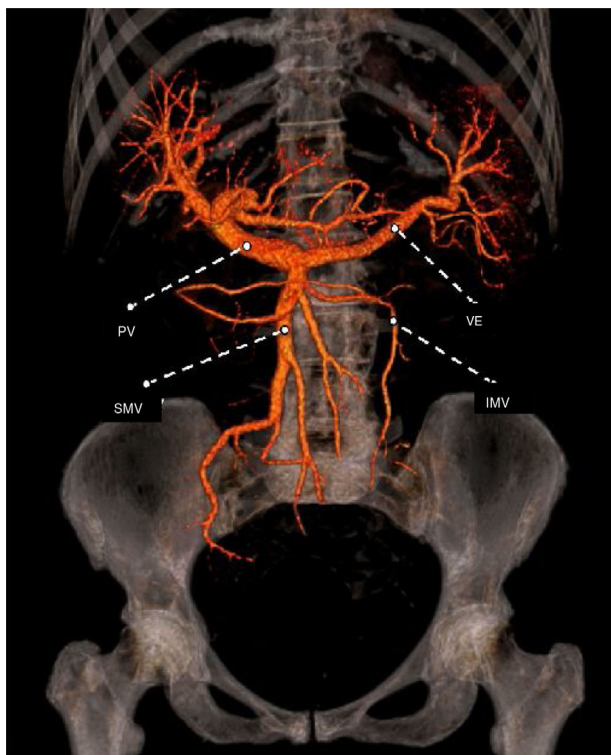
Coronal view of the reconstruction of the portal, splenic, and mesenteric vein system through MD-CT with volume rendering.
